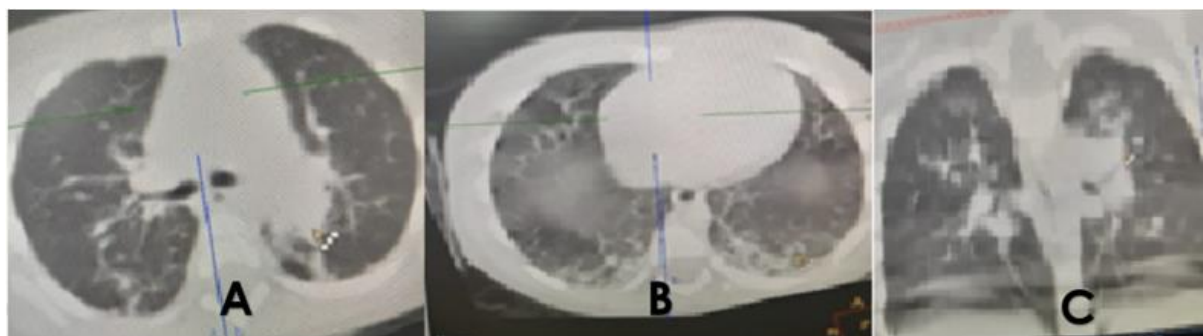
Thoracic CT in axial sections (A, B) and coronal reconstruction (C) revealing frank pneumonia of the ventral segment of the left upper lobe (A, C) associated with foci of alveolar filling of the postero-basal segments of the lower lobes (B).
